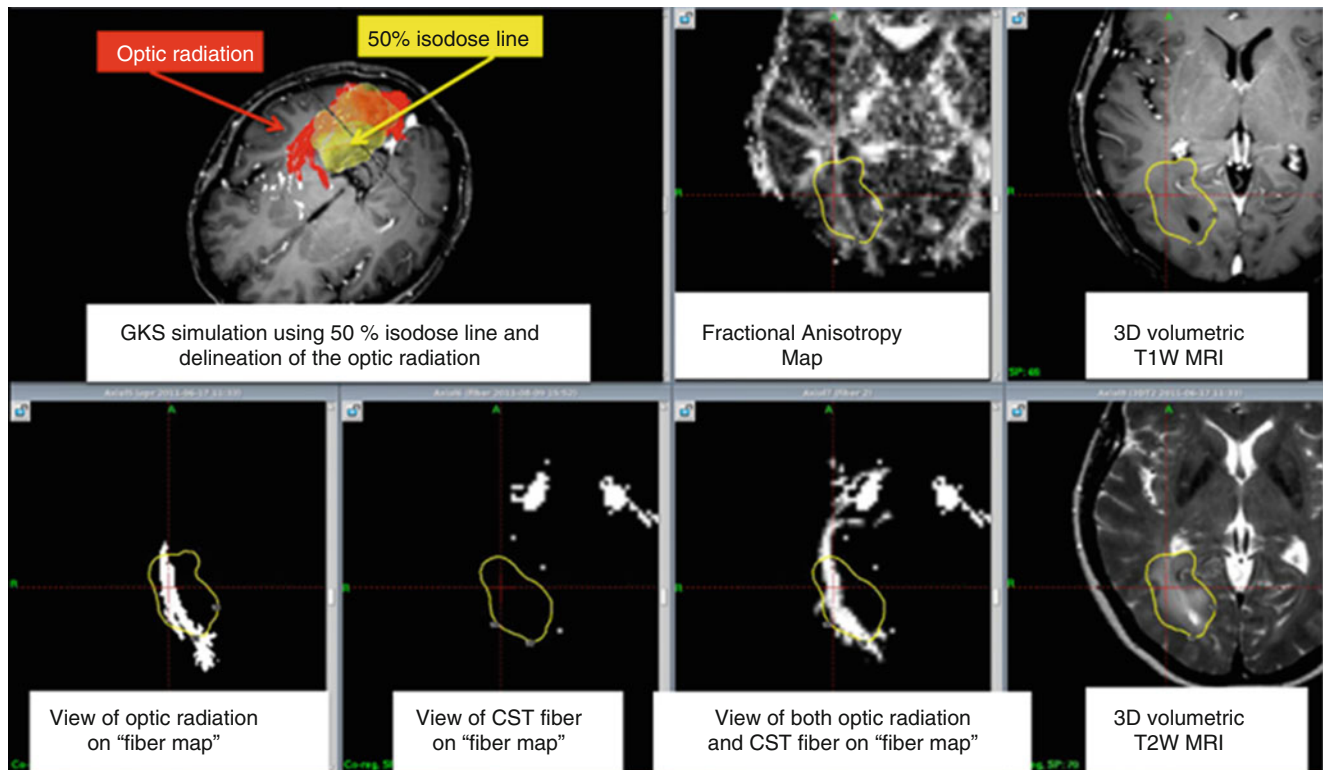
Installation of the fractional anisotropy map and fiber tracking images (“fiber map”) into LGP and their 3D co-registration with T1- and T2-weighted MRI scans in a patient with a right parieto-occipital glioma.
